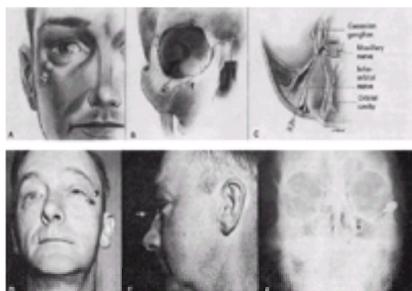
Maxillary nerve block by the orbital (Matas) route. A: An 8-cm, 22-gauge needle is introduced through a wheal made just above the inferior orbital margin, 1 cm medial to the inferior lateral angle of the orbital rim. Contact with the floor of the orbit is made, and the needle is advanced posteriorly and slightly medially, keeping constant contact with the bone. B: At a depth of about 3.5 cm, the point of the needle enters the inferior orbital fissure and loses its contact with bone. C: The needle is then slowly advanced so that its point passes through the pterygopalatine fossa, and it finally enters the foramen rotundum at a depth of about 5 cm. Paresthesia can be elicited while the needle is advancing through the pterygopalatine fossa and should always be elicited when the needle enters the foramen rotundum containing the nerve. D,E: Patient with the needle in place. F: Radiograph showing the bevel of the needle within the foramen rotundum. Injection of 0.5 mL of alcohol is sufficient to destroy the nerve.
